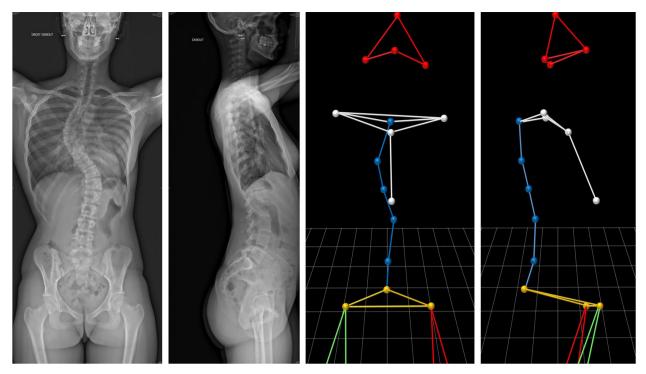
Female with Lenke 1 scoliosis: standard radiographs on the left and quantitative gait analysis-based reconstruction in the coronal and sagittal planes on the right.
